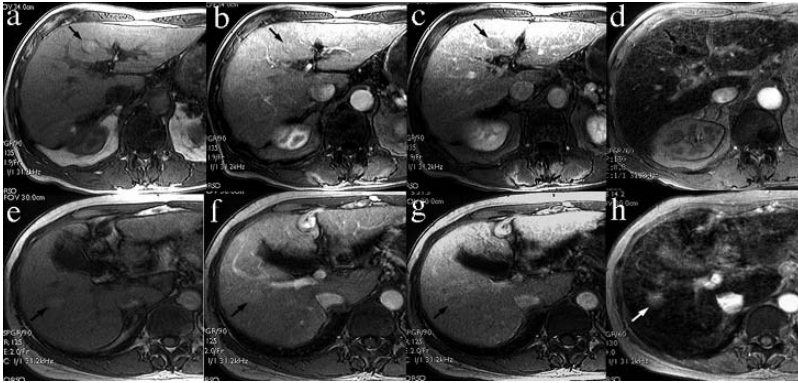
Comparison between dynamic MR imaging and SPIO-enhanced MR imaging in differentiating borderline lesions. Dysplastic nodule in a 75-year-old male (a–d) and, well-differentiated HCC in a 65-year-old male (e–h). On pre-contrast T1W-GRE, both lesions (a and e, arrows) exhibit high intensity and are hypovascular on dynamic MR imaging (b, c, f, and g; arrows), and they cannot be distinguished from each other. On SPIO-enhanced MR imaging, DN takes up SPIO (d, arrow) but HCC exhibits decreased phagocytic activity (h, arrow).
